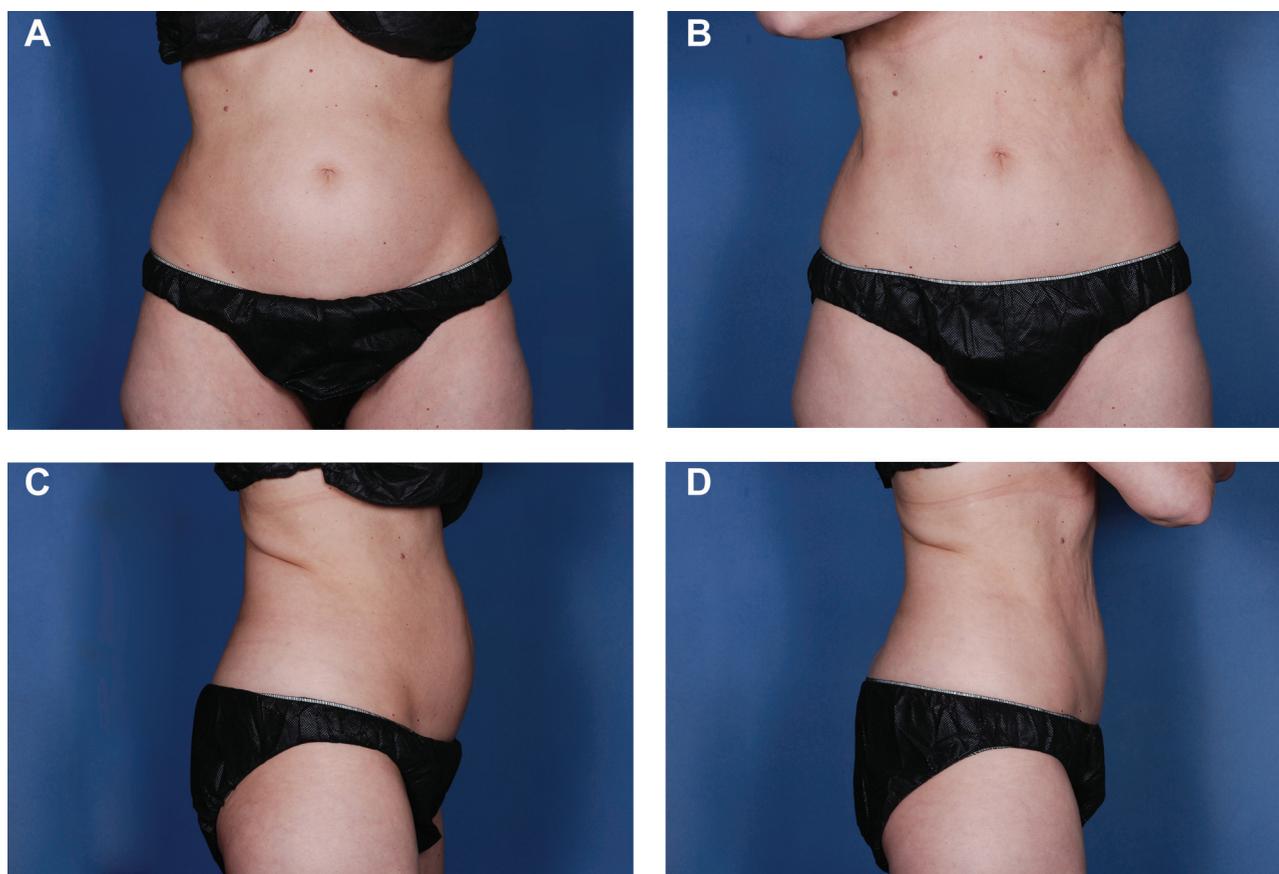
(A, C) This 52-year-old woman presented for treatment with high-intensity focused ultrasonography. (B, D) Twelve weeks after treatment with 3 passes of 59 J/cm². From baseline to 12 weeks posttreatment, her waist circumference decreased by 2.5 cm and her weight increased by 0.8 kg.
